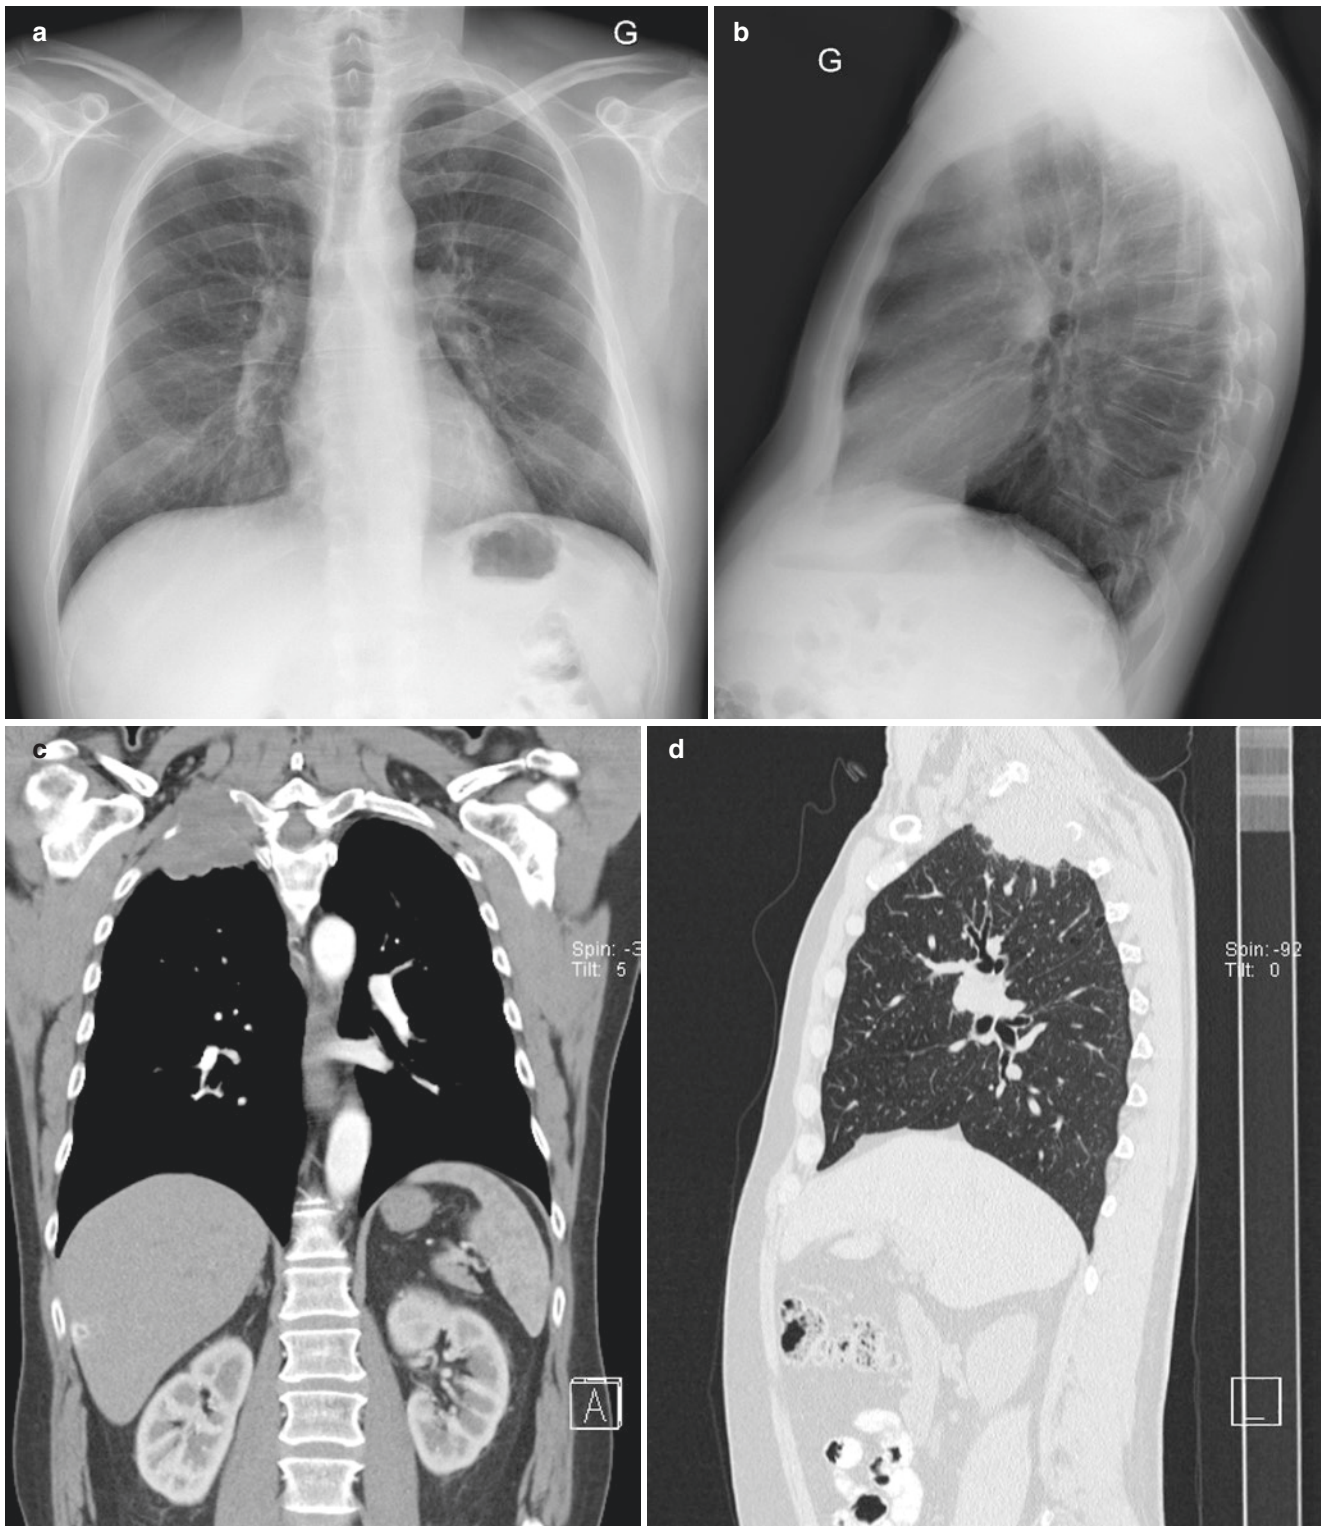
A 53-year-old man who underwent chest radiography for pain in the right axilla. Postero-anterior (a) and lateral (b) radiographs interpreted as normal. With hindsight bias from MDCT the right apical mass is obvious. MDCT coronal and sagittal images with soft tissue (c) and bone (d) windows showing a right apical mass with bone destruction
